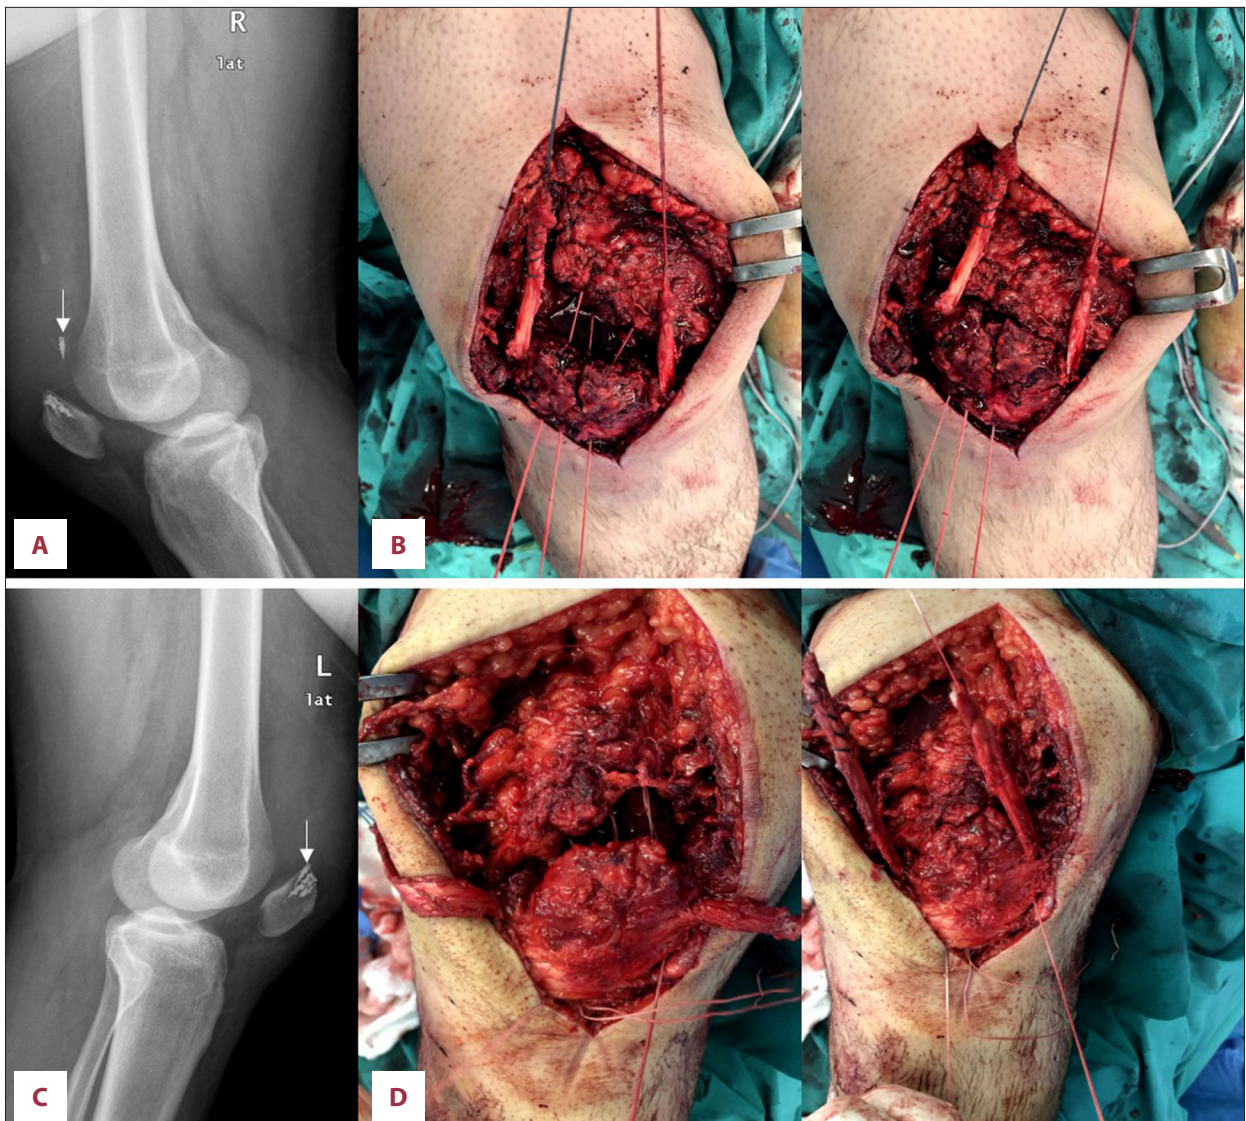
(A, C) Lateral radiographs at 3.5 months follow-up, after the new incidence of bilateral ruptures of quadriceps tendons, showing mild ossification, patella baja and pull-out of 1 of the anchors in both knees (arrows), (B, D) intraoperative pictures of both knees showing the transosseous drill holes in the patella; the quadriceps tendons were reapproximated while pulling the sutures, and each limb of the middle tunnel was firmly tied with the ipsilateral pair of the medial and lateral sides. The Achilles tendon allograft that had passed in the middle of the patella prior to drilling was then passed through quadriceps substance and was sutured to itself in 60 degrees of flexion.
